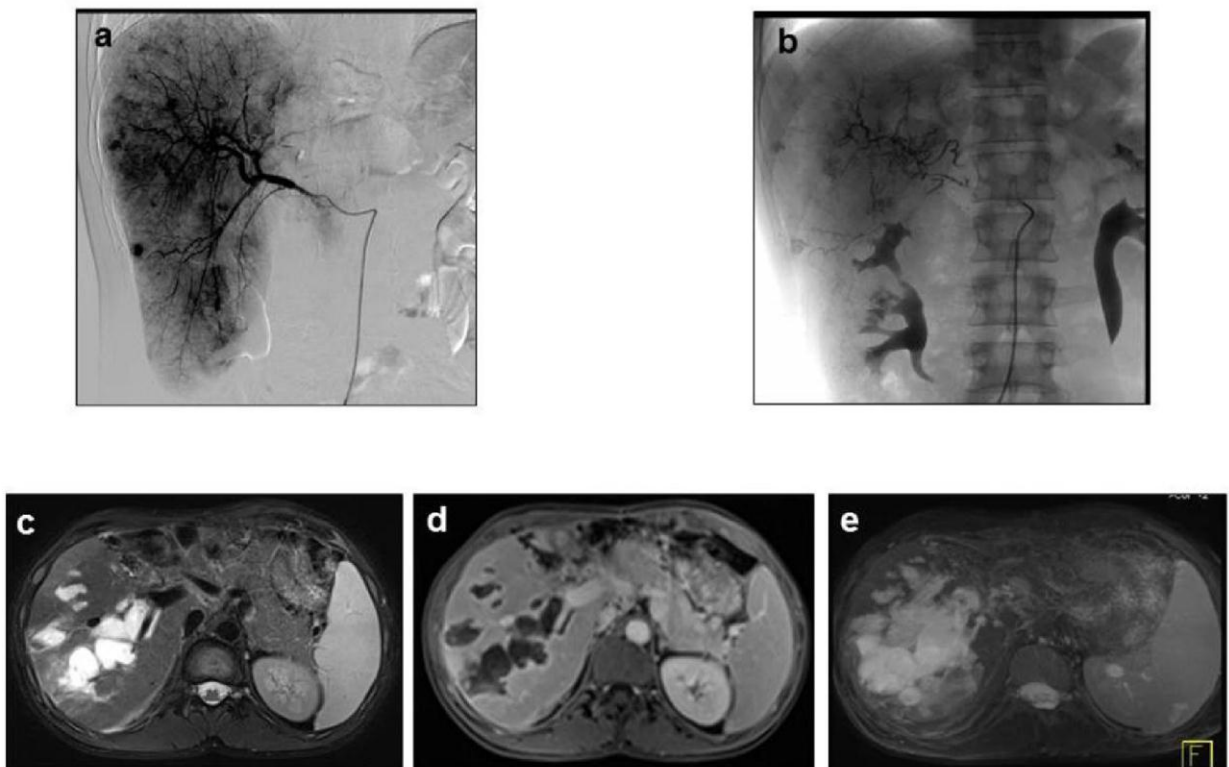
Cystic transformation of bile ducts. 32 years old male hepatocellular carcinoma patient underwent TACE for multiple recurrent tumors in the liver remnant: (a) hepatic arteriography, (b) accumulation of the iodized oil in the right liver lobe. MRI two months after TACE: T2-WI (c), contrast enhanced T1-WI (d) and MIP (e) demonstrate almost totally cystic dilated bile ducts, periductal edema and hepatic parenchyma inflammation.
